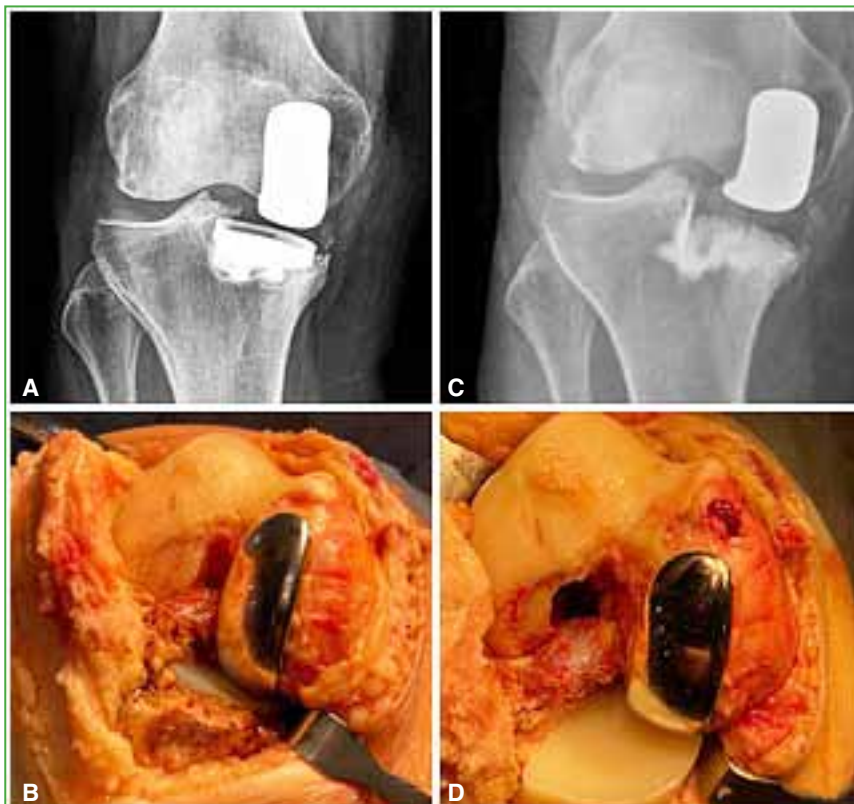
Revision of the UKA tibial component to a new UKA tibial plateau due to mechanical prosthetic loosening of the tibial component after 7 years. A. Anteroposterior radiograph of the right knee. Loosening and subsidence of the tibial component. B. Intraoperative image. The loosening of the metallic tibial plateau and the indemnity of the remaining joint structures were confirmed. C. Anteroposterior right knee radiograph after revision to an internal unicompartmental prosthesis with an *all-poly* tibial component. D. Intraoperative image of the revision of the unicompartmental tibial component.
